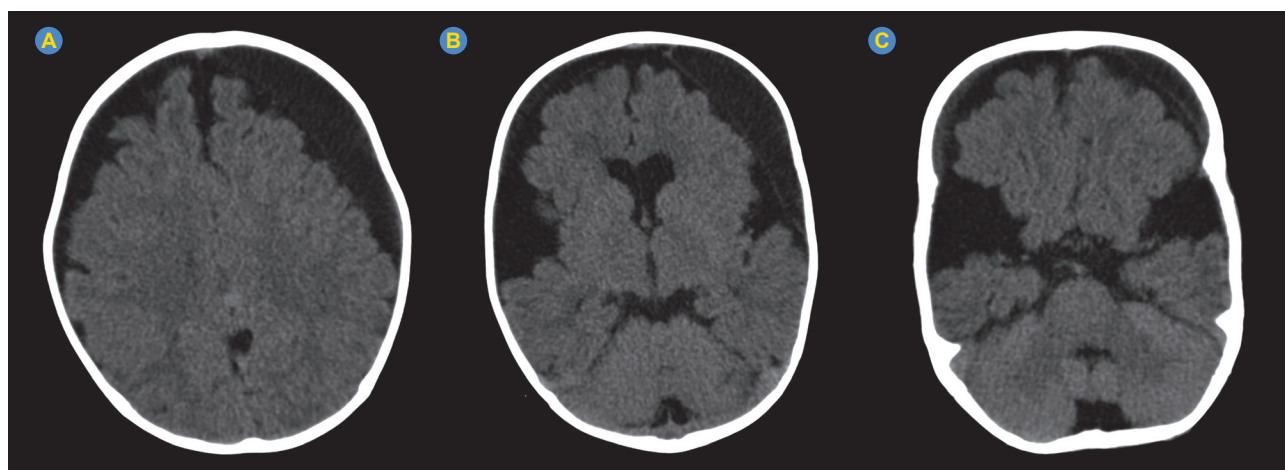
Cranial CT-scan at 11 months of age (A - C) showing further reduction in size of the subdural hematoma on the right frontotemporal convexity, without any signs of re-bleeding.
